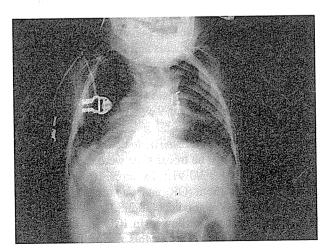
Post operative X-Ray of the patient with scoliosis
